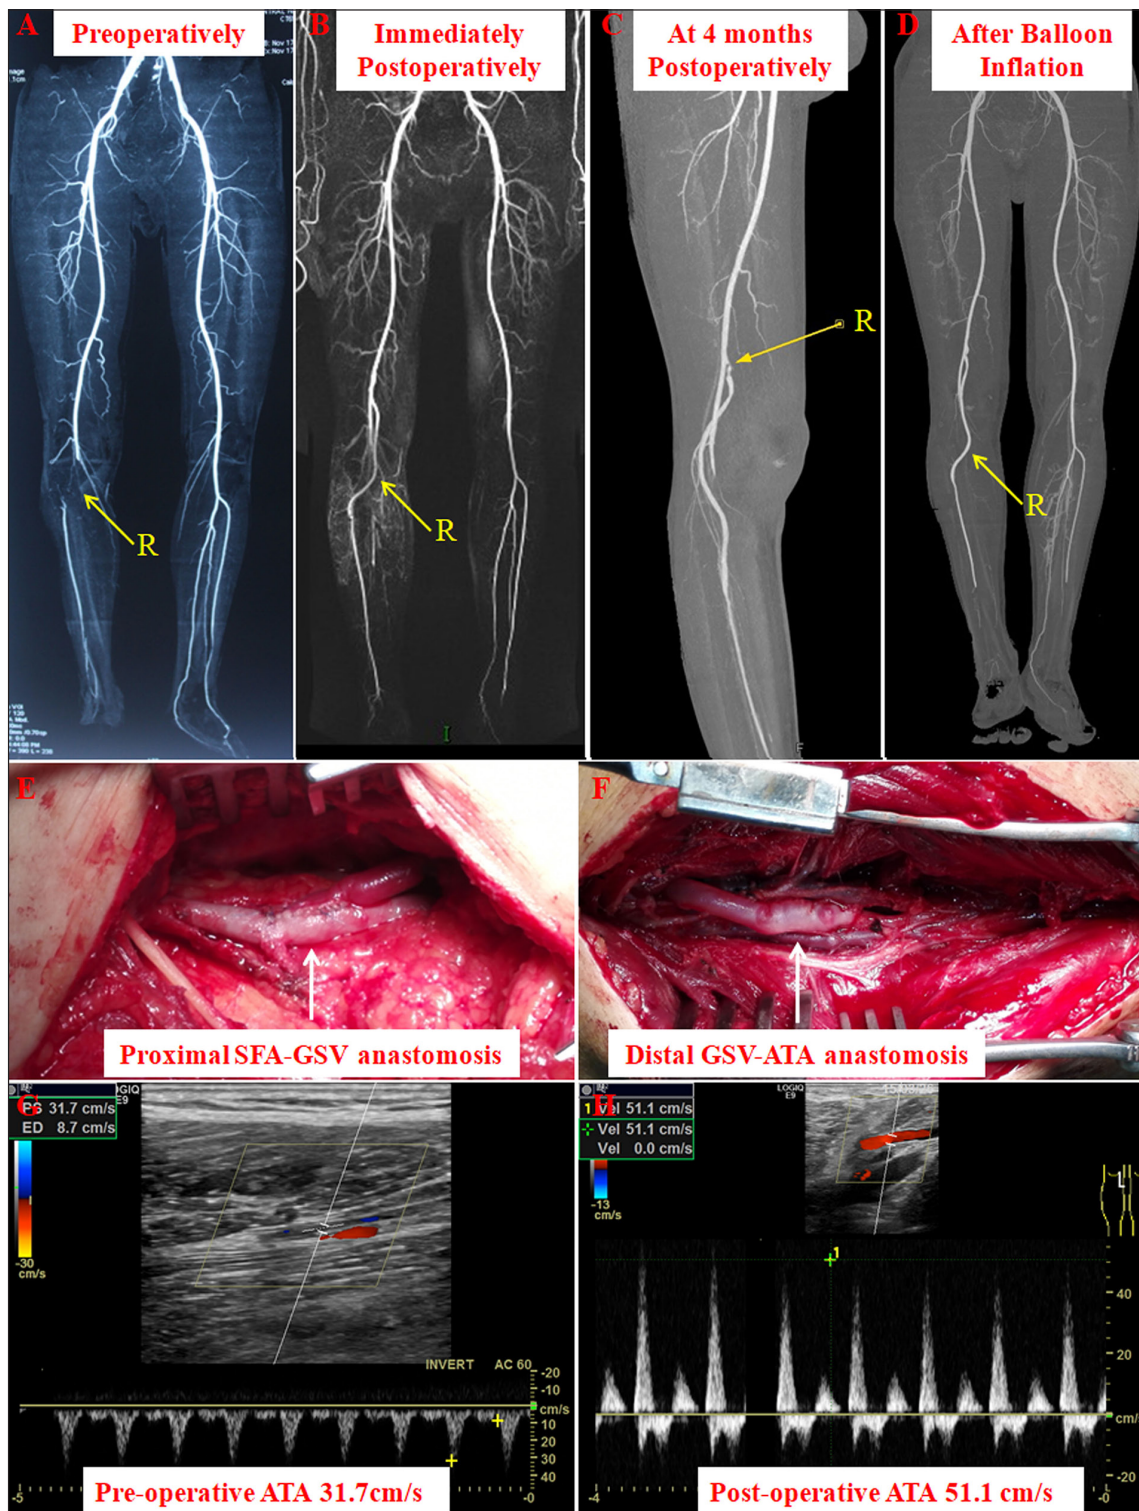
A 36-year-old man who was an active smoker, presented with intermittent claudication due to TAO (A), and underwent below-knee revascularization (B). A reversed saphenous vein graft was anastomosed end-to-side to superficial femoral artery (E) and anterior tibial artery (F). There was an obvious elevation on peak flow velocity in anterior tibial artery from 31.1 to 51.1 cm/s following the procedure (G, H). CTA was indicative of anastomotic inflow stenosis after a follow-up period of 4 months (C), and balloon inflation was used to resolve the stenosis (D). Graft failure occurred on the postoperative 7 months (no images available). No revision was attempted, and he was asymptomatic. Abbreviations: GSV, great saphenous vein; SFA, superficial femoral artery; ATA, anterior tibial artery.
